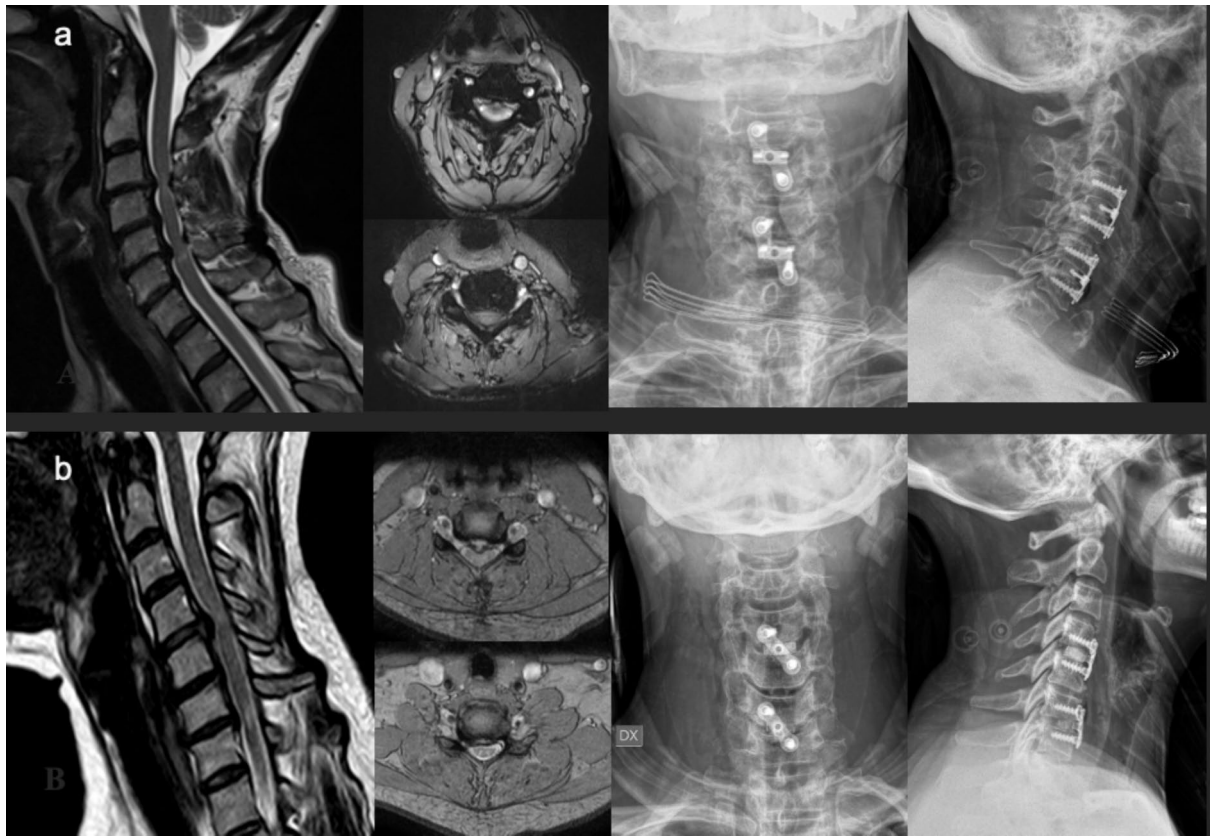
Example of two patients (“a” and “b”) who presented non-contiguous 2-level myelopathy. On the left of each line, there is the preoperative MRI, while on the right there are the postoperative
